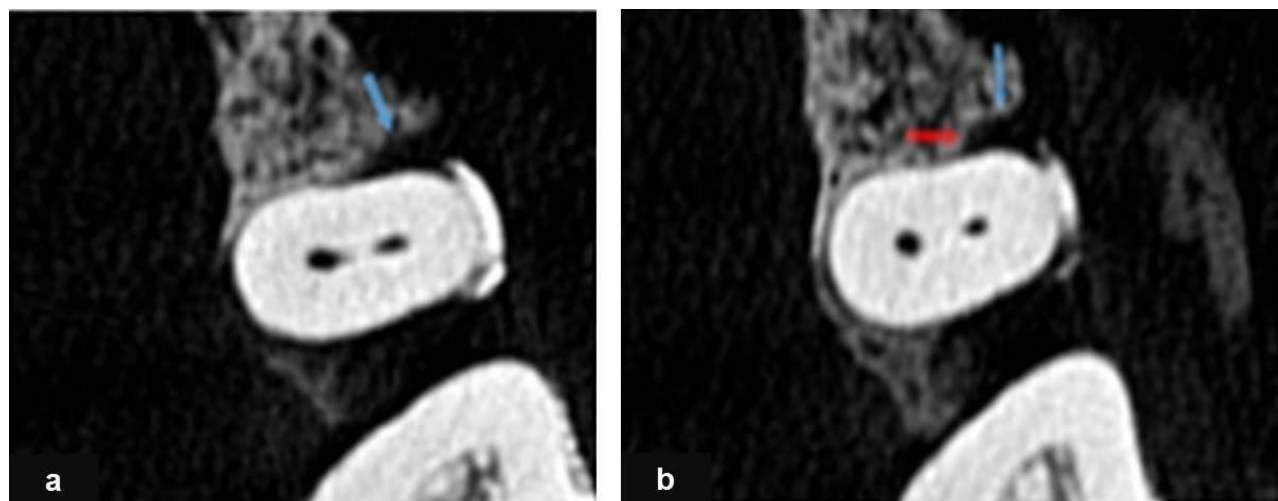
CBCT axial cuts showing Combined angular bone defect mesial to upper left second premolar starts as one wall defect (distal wall) and converted into two walls defect (distal and palatal) when go moreapically
